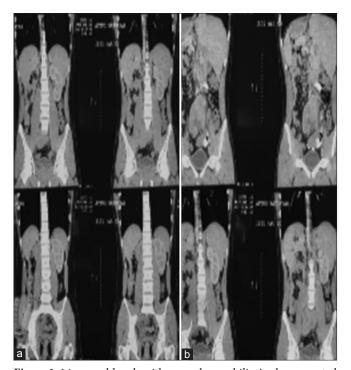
14-year-old male with severe hemophilia A who presented with hematuria. (a) Contrast-enhanced computed tomography scan of the abdomen showed an ectopic kidney located in the left pelvic region. (b) There is also the presence of delayed enhancement and retention along with peripheral inflammatory changes in the left malrotated kidney.
